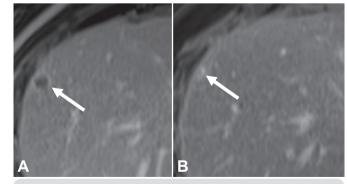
Suspicious hypovascular lesion on dynamic CT. A) portalvenous phase showing subtle peripheric enhancement (arrow).
